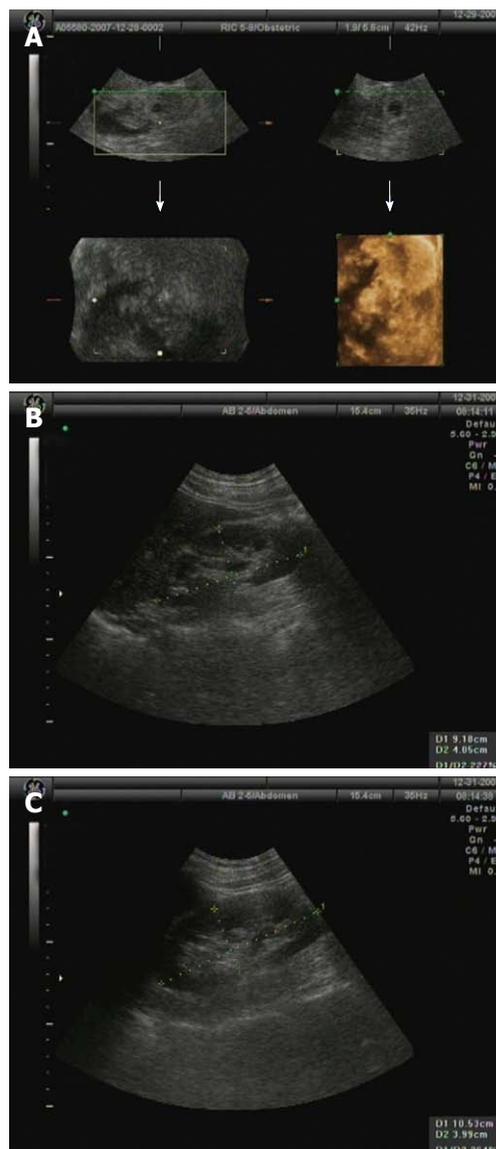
Abdominal and kidney ultrasonography showing no mass and fluid collection (A), left (B) and right (C) normal kidney structure.
